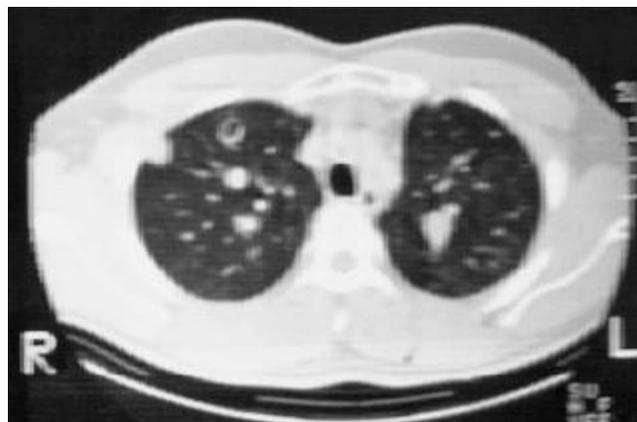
Transverse thin section CT scan obtained at the level of aortic arch shows multiple, well defined nodular lesions of varying sizes, distributed in peribroncho-vascular and sub-pleural locations in both upper lobes.
